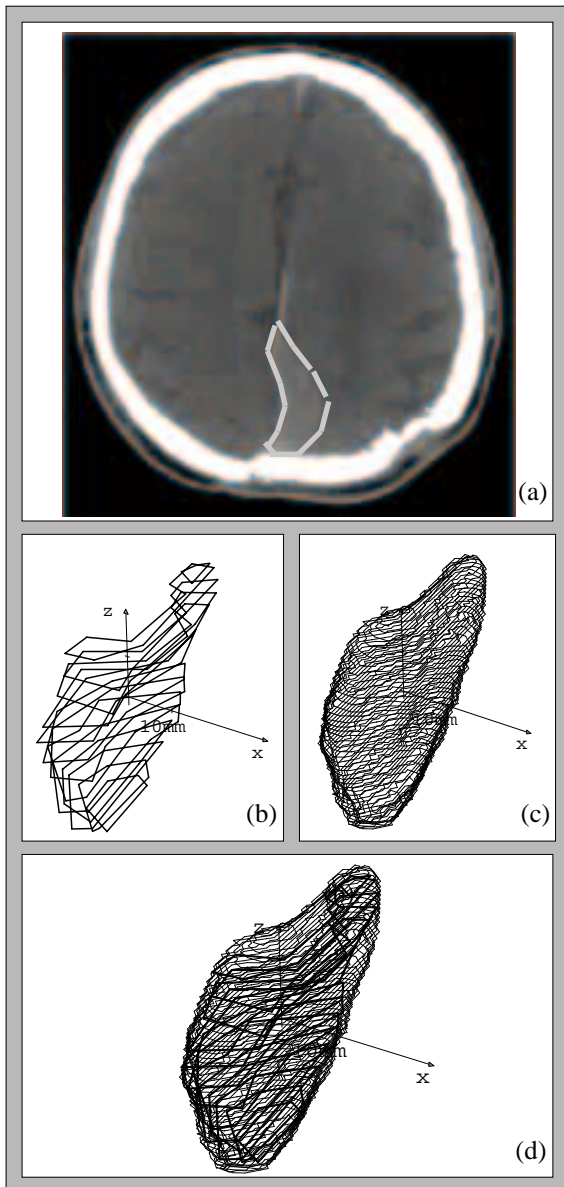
Sample case (Stanford Medical Center). (a) Axial CT with tumor delineated in black (b) 3D representation of tumor delineation (c) Isodose surface (d) Isodose surface overlaid on tumor reconstruction
